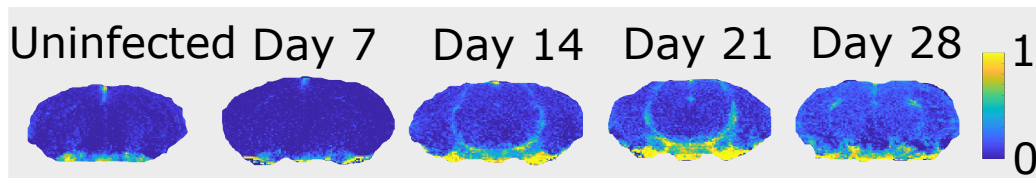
Contrast enhanced MRI images for Study 3
